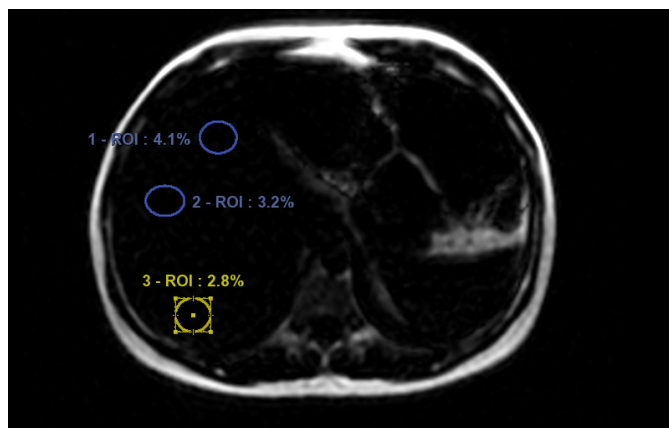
(B). MRI Abdomen Showing Different Regions of Interest (ROI) from Liver Showing Fat Fraction in the Liver in a Patient with a Healthy Liver.
